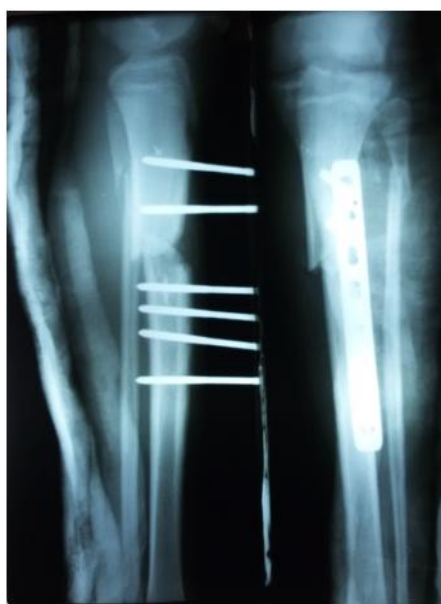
Post-op X-ray showing correction of length, alignment and rotation with rigid fixation.
